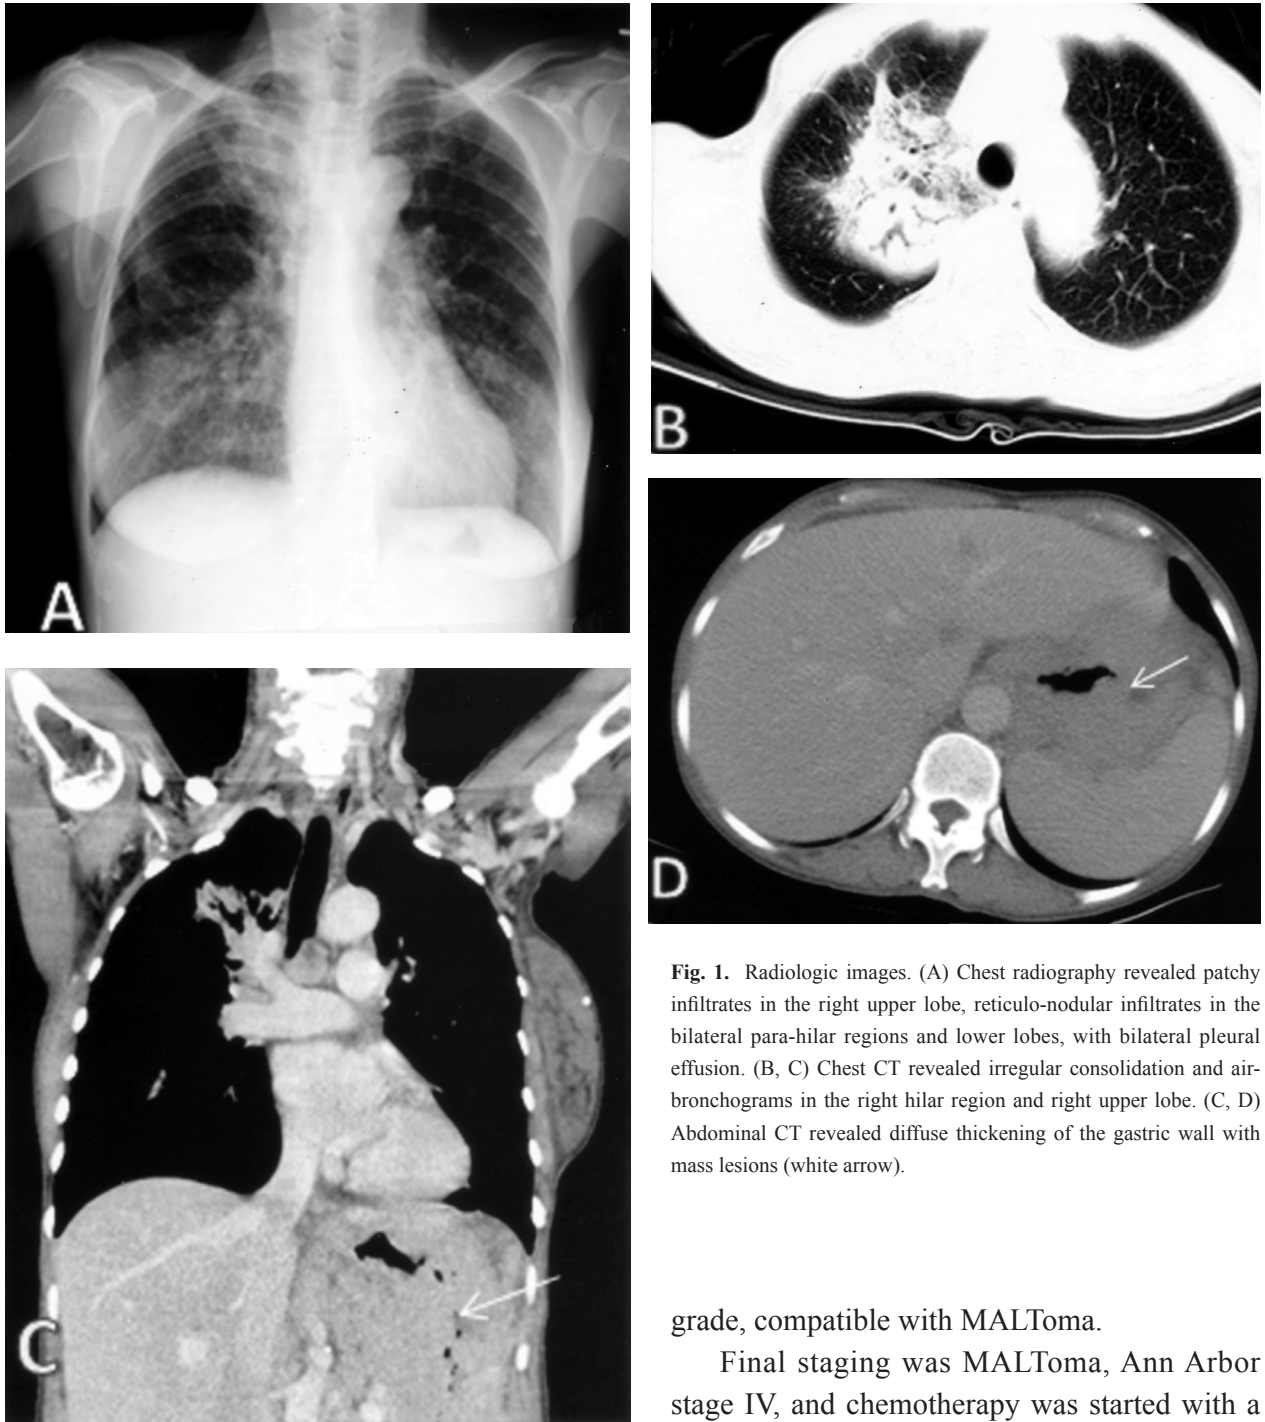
Radiologic images. (A) Chest radiography revealed patchy infiltrates in the right upper lobe, reticulo-nodular infiltrates in the bilateral para-hilar regions and lower lobes, with bilateral pleural effusion. (B, C) Chest CT revealed irregular consolidation and air-bronchograms in the right hilar region and right upper lobe. (C, D) Abdominal CT revealed diffuse thickening of the gastric wall with mass lesions (white arrow).
